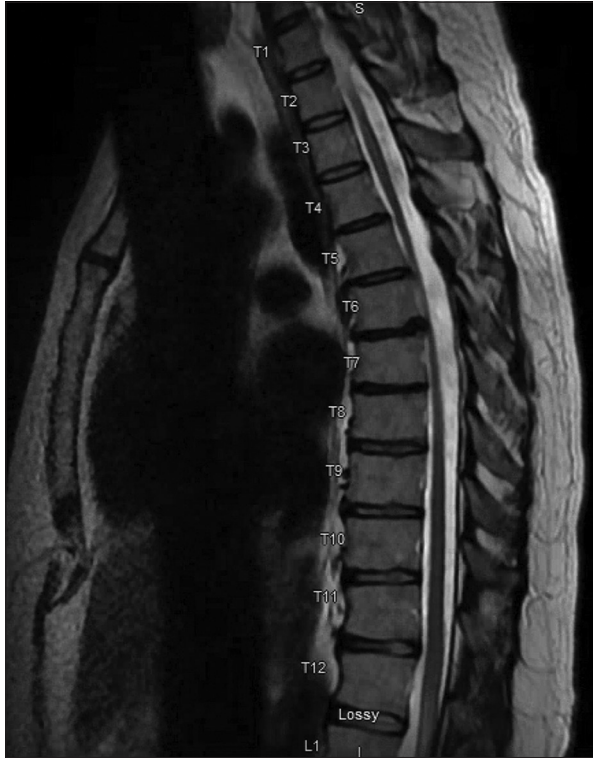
Follow-up sagittal T2-weighted MRI of the thoracic spine at 10 months. Significant improvement in spinal cord edema compared to initial imaging [Figure 2a].
